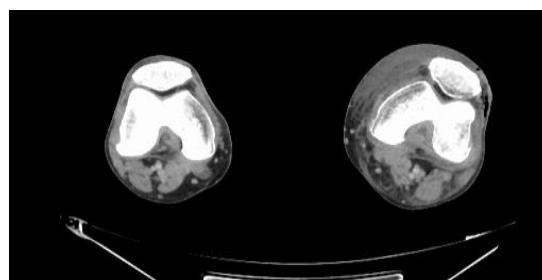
CT images - cross section with free gas: Patellar.
